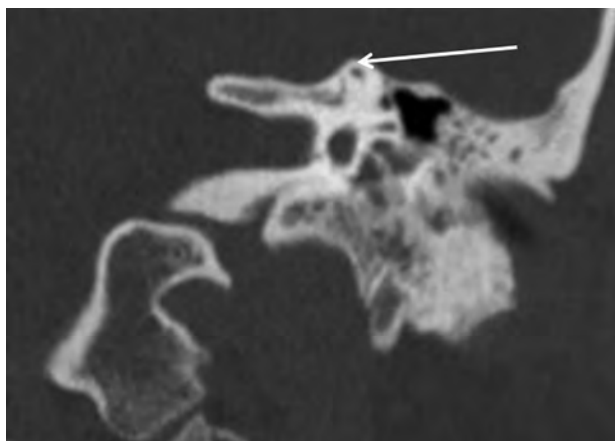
Intact superior semicircular canal. Coronally reformatted CT of the temporal bone demonstrates an intact roof of the superior semicircular canal (arrow).
